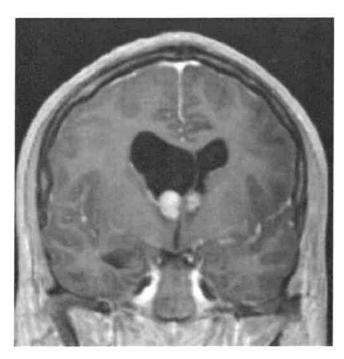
Bilateral subependymal giant cell astrocytoma with ventricular enlargement. Contrast-enhanced MRI.
